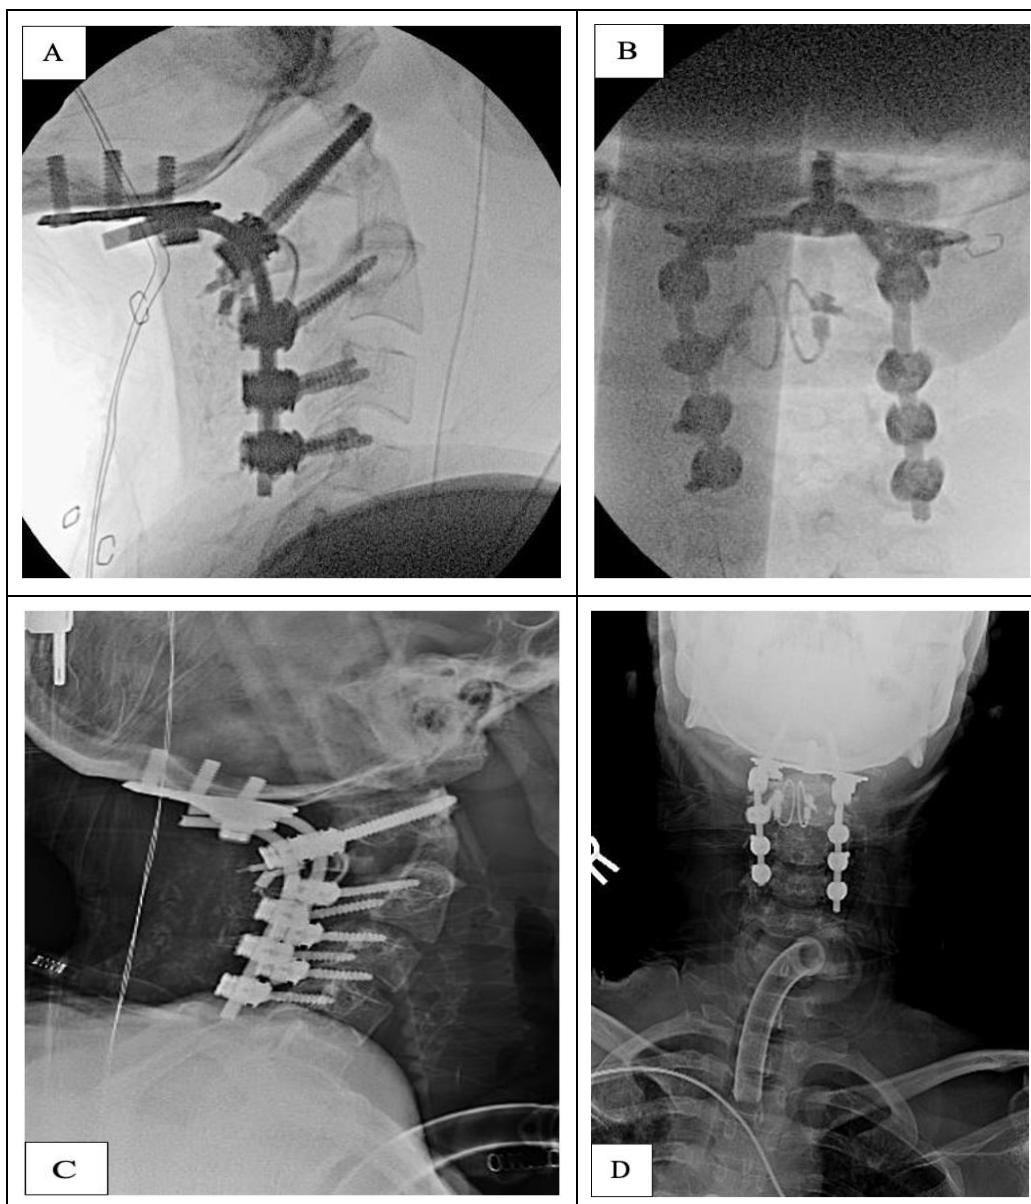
(A): Lateral and (B): AP intraoperative fluoroscopic images and (C): Lateral and (D): AP post-operative radiographs demonstrating a posterior cervical fusion from occiput to C4.
